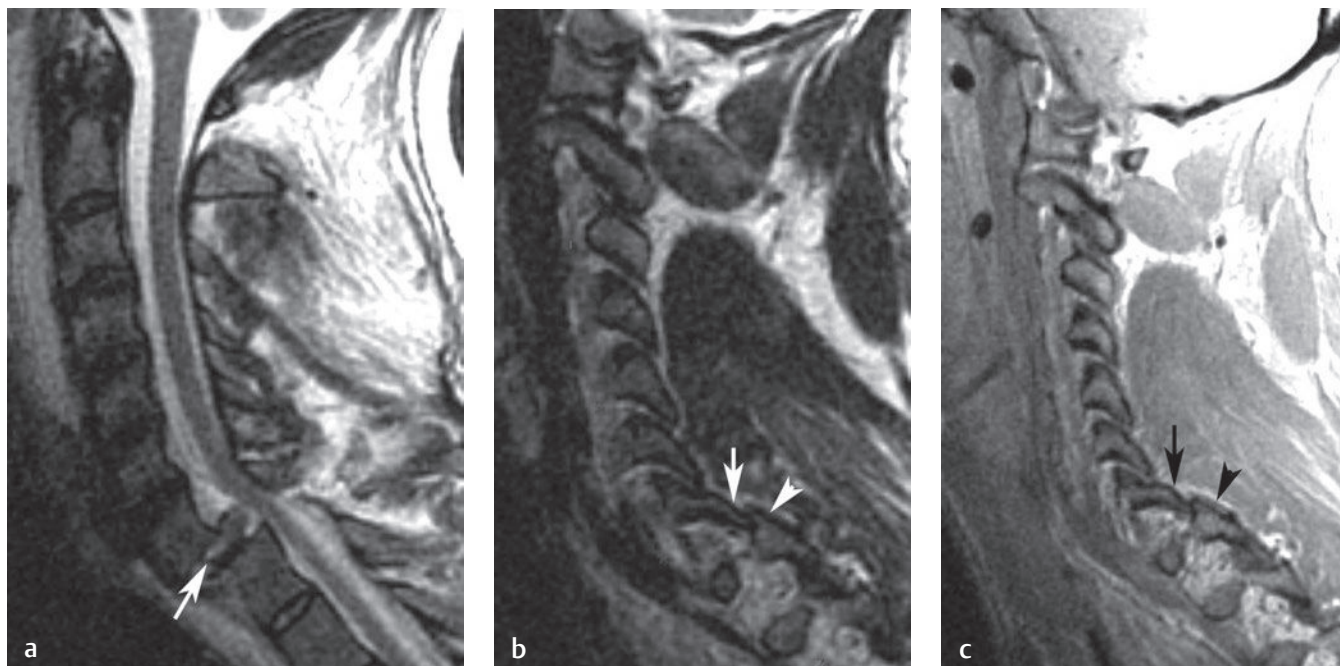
Bilateral cervical facet dislocation. (a) A sagittal T2-weighted image shows anterior translation of C7 over T1 with an associated disc extrusion (arrow) and cord compression. (b) Parasagittal T2-weighted and (c) gradient-echo images show the inferior articular process of C7 (arrow on each) displaced anterior to the superior articular process of T1 (arrowhead on each).[†]
